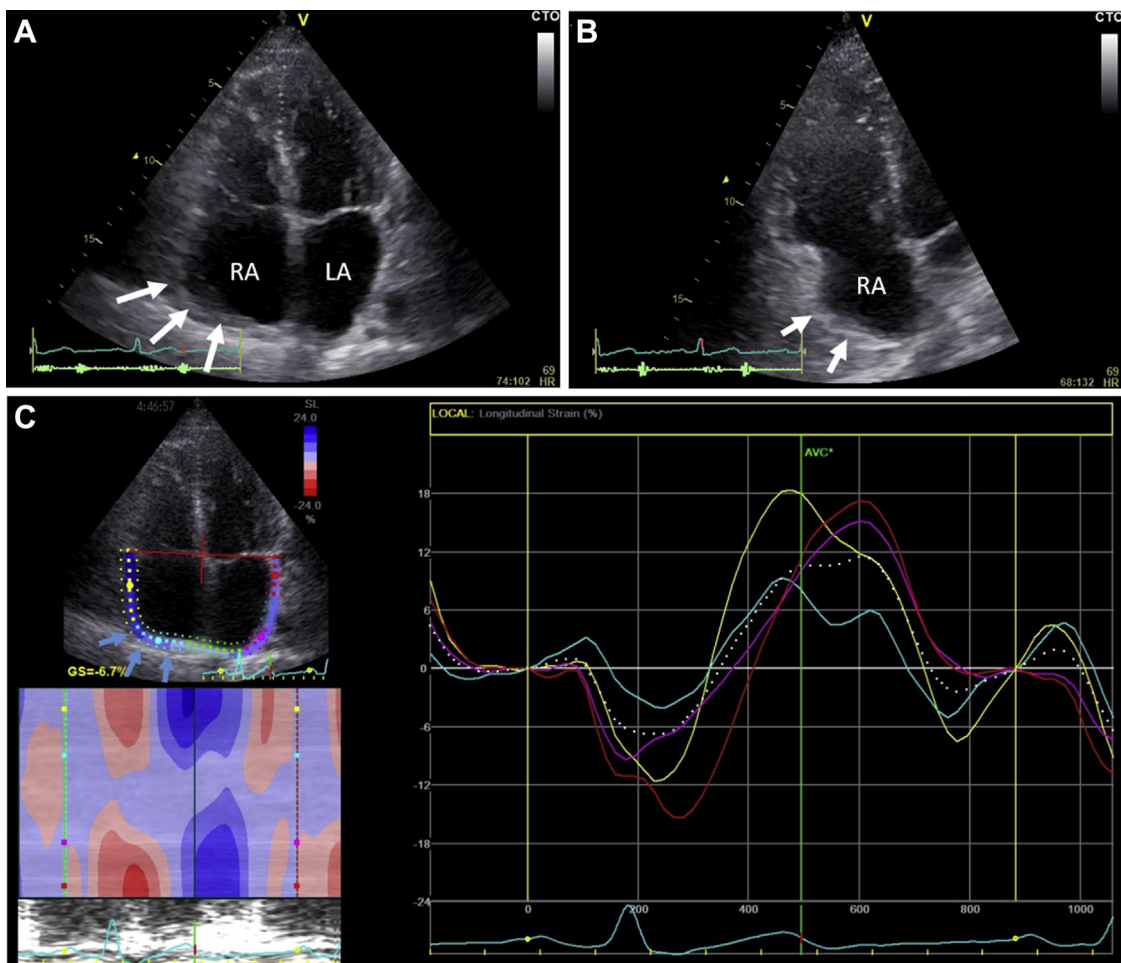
Transthoracic echocardiography during sinus rhythm. A, B: Apical 4-chamber view (A) and focused view of the right side of the heart (B). The right atrium is dilated compared to the left atrium. The right atrial free wall expands outward (*white arrows*). C: Atrial strain curves with speckle-tracking echocardiography. Atrial function is regionally decreased at the right atrial free wall (*light blue arrows*). In other atrial areas, including the left atrium, the atrial function is preserved. LA = left atrium; RA = right atrium.
